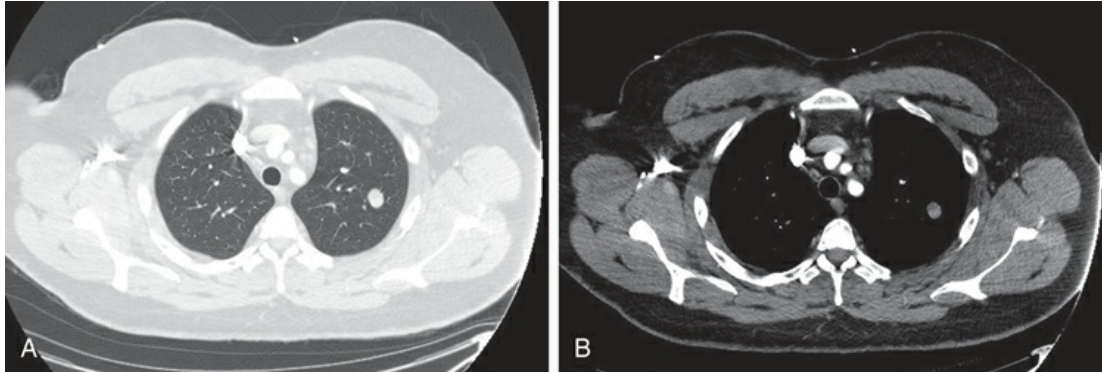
Cross-sectional (axial) images from a computed tomography (CT) scan showing a solitary pulmonary nodule in the left lung. Images are displayed using different “windows” at the same cross-sectional level. A, Settings were chosen to optimize visualization of lung parenchyma. B, Settings were chosen to distinguish different densities of soft tissues, such as structures within mediastinum. Iodinated contrast allows vascular structures in the mediastinum to be readily identified.
